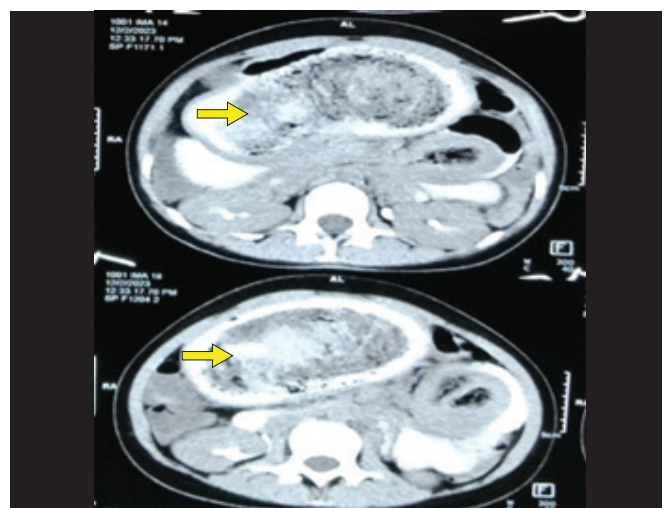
Axial section of CT scan shows a giant bezoar occupying almost entire the lumen of the stomach
